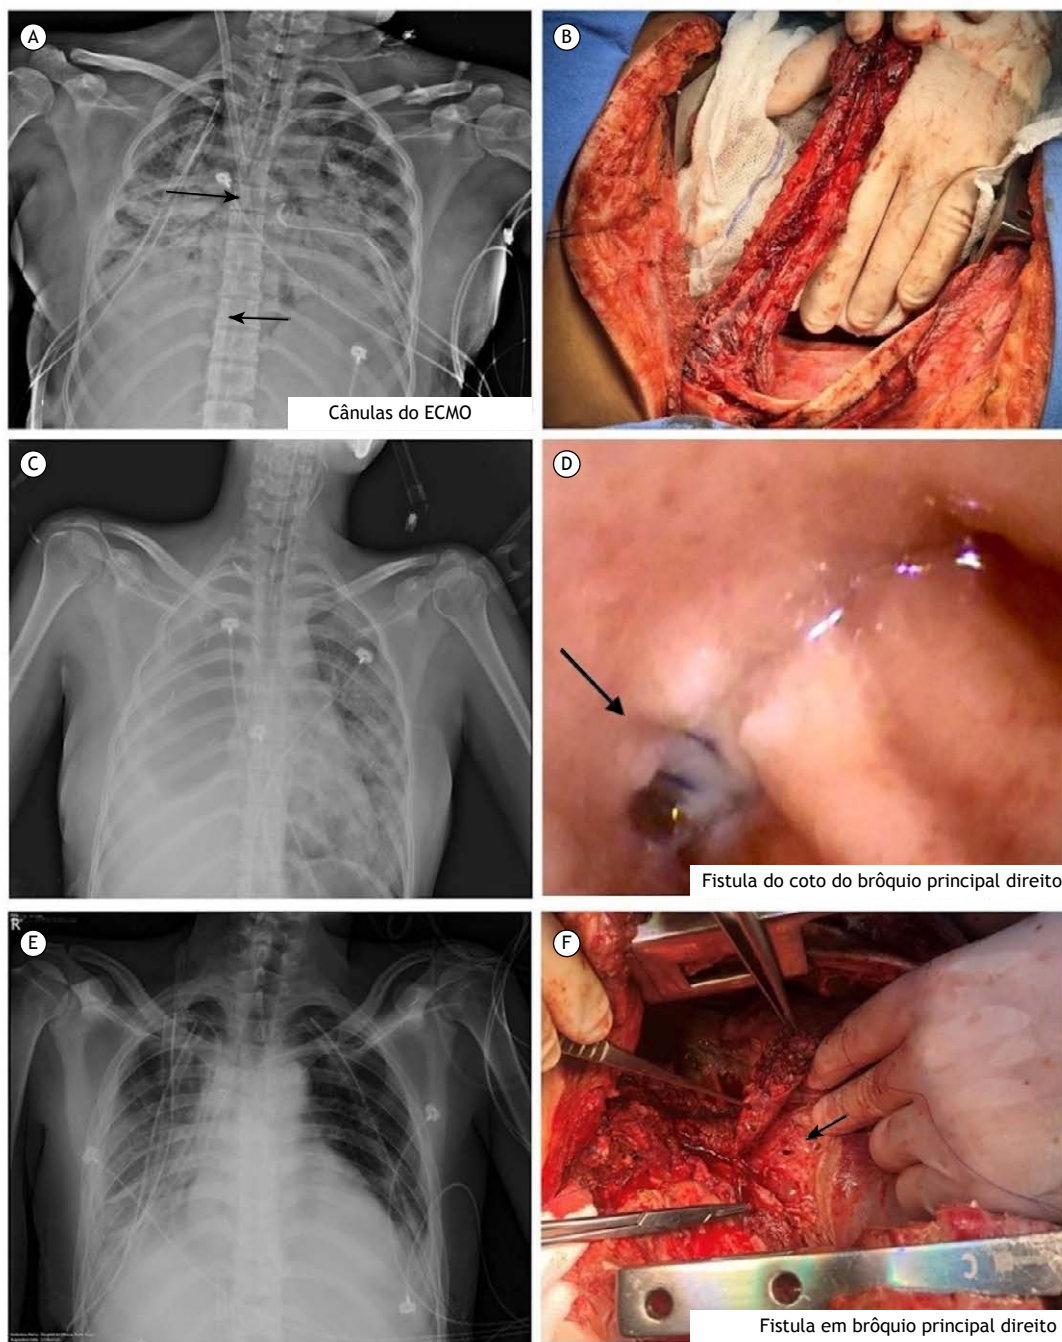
Images of the described case reports. Case 1: (A) chest X-ray with arrows indicating the position of the ECMO cannulas; (B) intercostal muscle flap. Case 2: (C) chest X-ray evidencing the pneumonectomy cavity to the right and pulmonary consolidations to the left; (D) right main bronchus stump with arrows indicating the location of the fistula. Case 3: (E) chest X-ray after cannulation of the right and left femoral veins; (F) arrow indicating the location of the fistula during the transoperative period.
